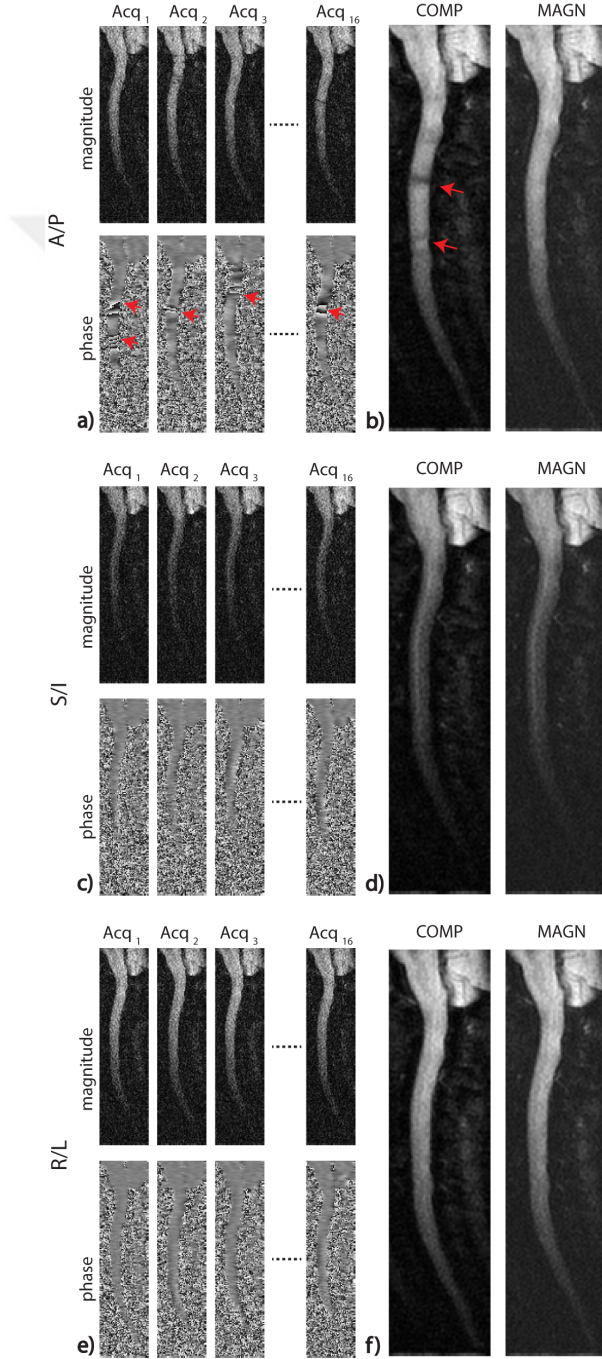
Local phase problems in DWI of the cervical spine for different diffusion-encoding directions. a,c,e) Magnitude and phase of each acquisition when diffusion-encoding is along A/P, S/I, and R/L directions, displayed following a global phase correction and a partial k-space reconstruction. b,d,f) The results of complex averaging (COMP) and magnitude averaging (MAGN) across multiple acquisitions. MAGN results in noise accumulation for all diffusion encoding directions. COMP, on the other hand, suffers from signal cancellations due to local phase problems (shown by red arrows), which are prominent when the diffusion-encoding is along the A/P direction. These phase problems occur at the positions where the nerve roots exit the spinal cord, which is consistent with the literature on nerve root pulsations in the same direction, synchronized to heart and CSF pulsations.
